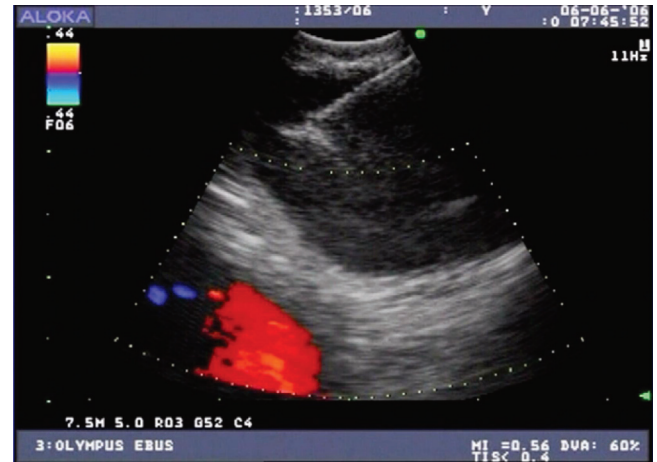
■ Endobronchial ultrasound-guided puncture of a node in 10R position. The needle is clearly visible within the lesion. The system also allows color Doppler assessment of unclear structures. (From Ernst A, Feller-Kopman D, Herth FJ: Endobronchial ultrasound in the diagnosis and staging of lung cancer and other thoracic tumors. *Semin Thorac Cardiovasc Surg* 19:201–205, 2007.)
